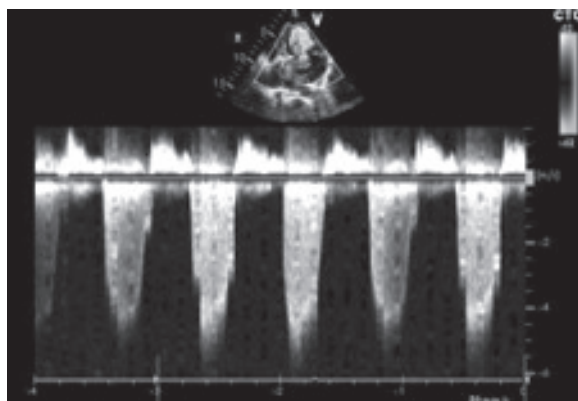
CW Doppler study showing severe MR
